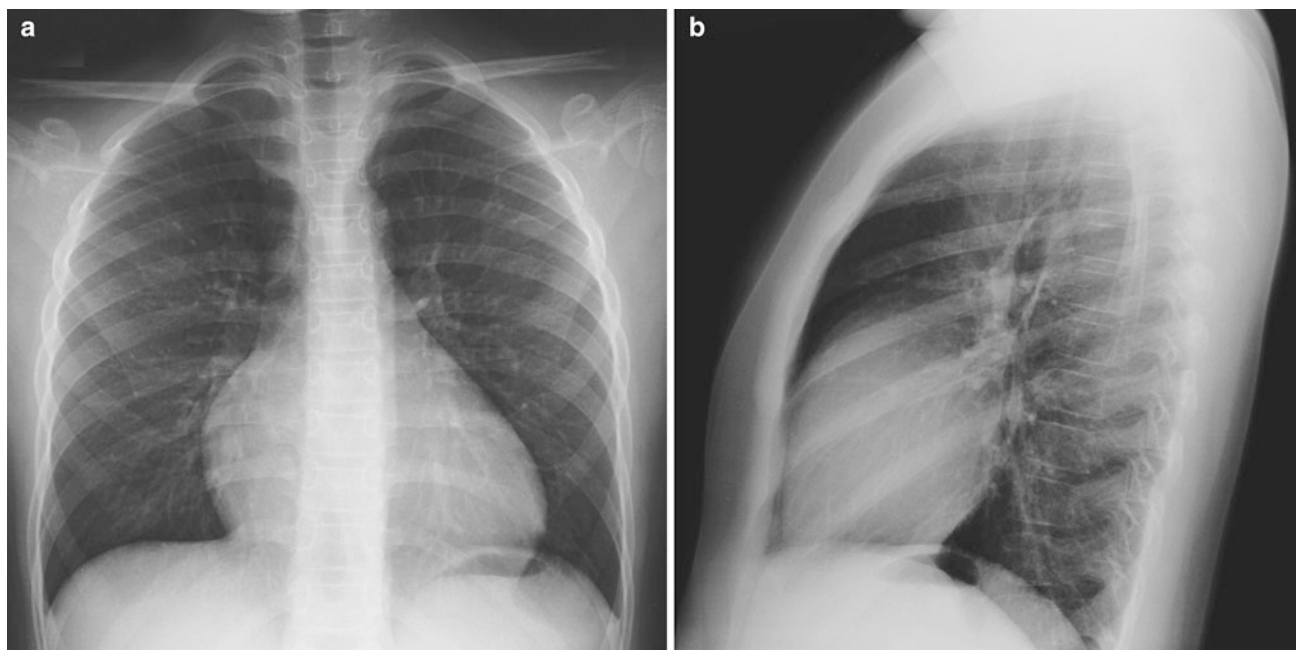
Frontal chest radiograph of a prominent heart (a). Lateral view shows wide contact of the anterior border of the heart with the sternum, indicating right ventricular enlargement (b)
